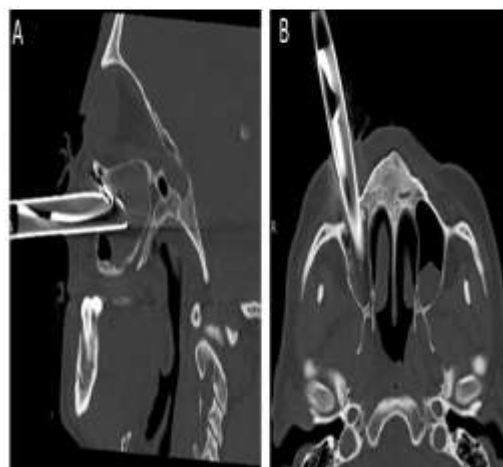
Sagittal (A) and axial (B) cut of the Computed Tomography of the face with hyperdense structure compatible with foreign body in the right maxillary sinus, with rupture of the anterior wall of the maxillary sinus.
